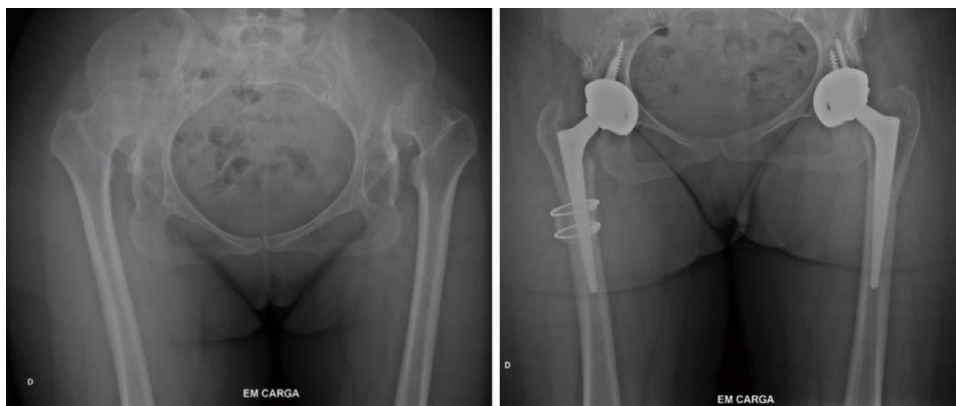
Example of patient MMMM. Radiographs before and after arthroplasties due to bilateral high dislocation.
